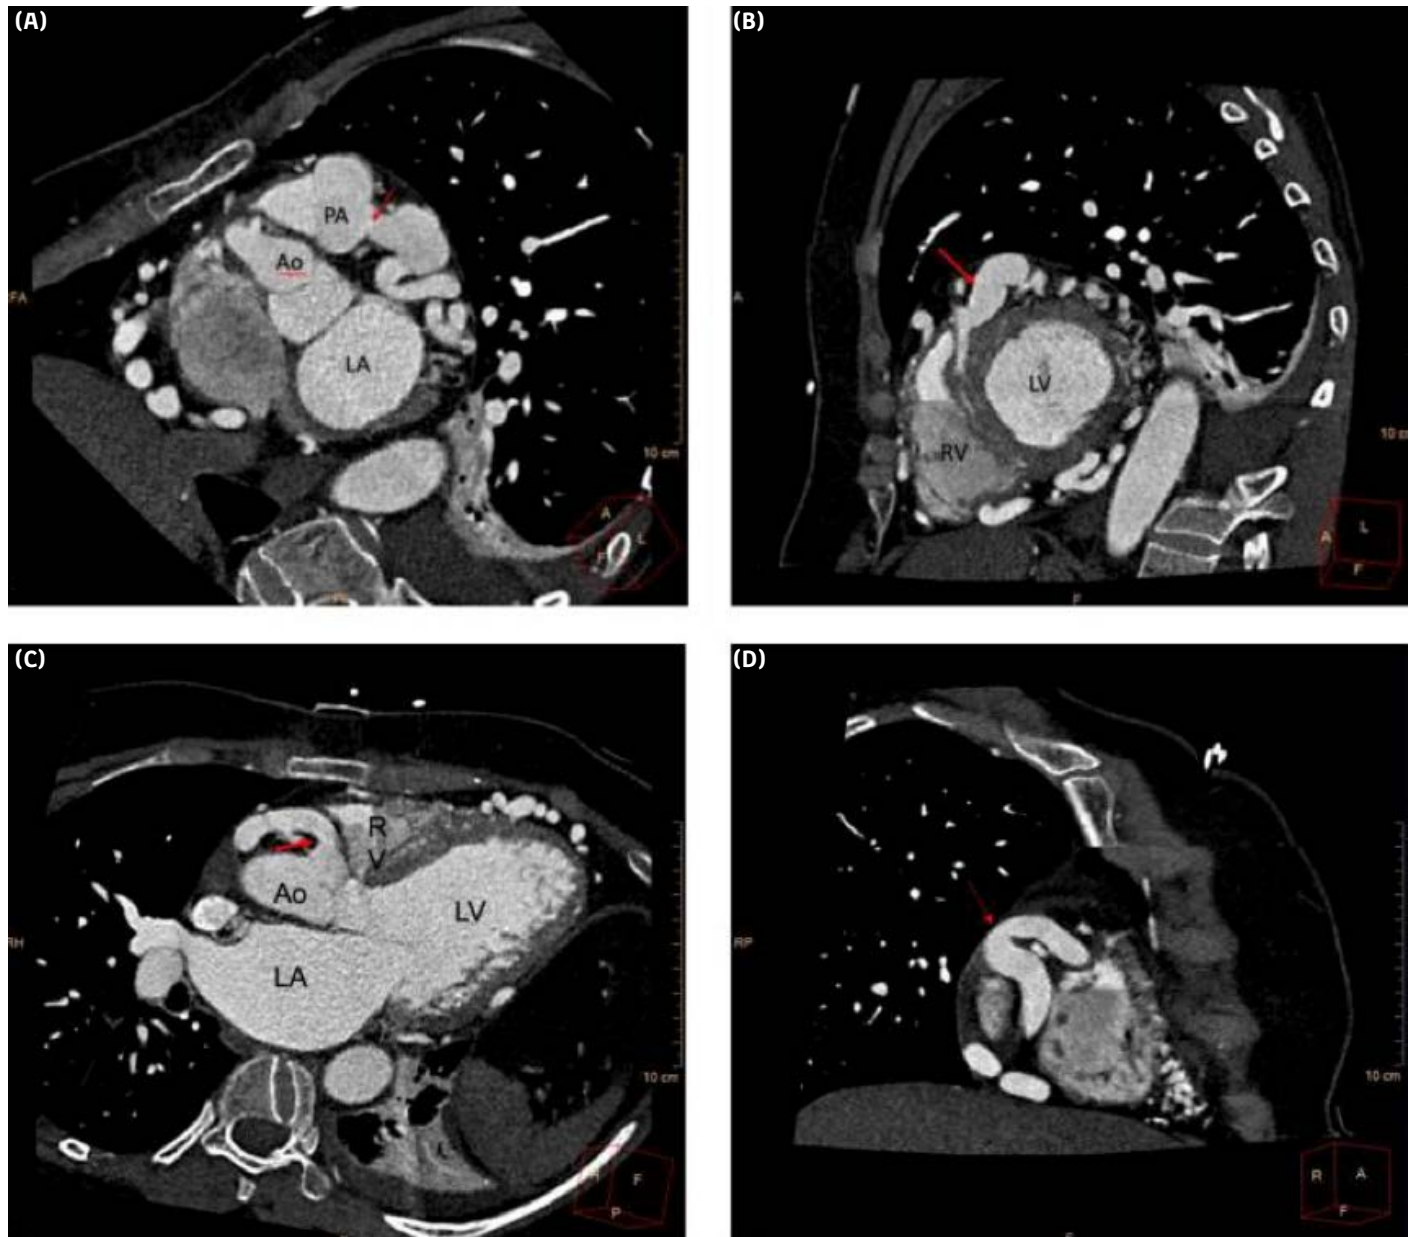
Coronary computed tomography angiography (CCTA) showing: (A) anomalous origin of the left coronary artery (red arrow) from the pulmonary artery (PA); (B) ectatic and tortuous left coronary artery (LCA) (red arrow); (C) normal origin of the right coronary artery (RCA, red arrow) from the right coronary sinus; and (D) diffusely ectatic coronary vasculature. Reproduced with permission from Prandi FR, Zaidi AN, LaRocca G, et al. Sudden Cardiac Arrest in an Adult with Anomalous Origin of the Left Coronary Artery from the Pulmonary Artery (ALCAPA): Case Report. *Int J Environ Res Public Health*. 2022;(3):1554. Licensed under Creative Commons Attribution (CC BY) 4.0 International License.
